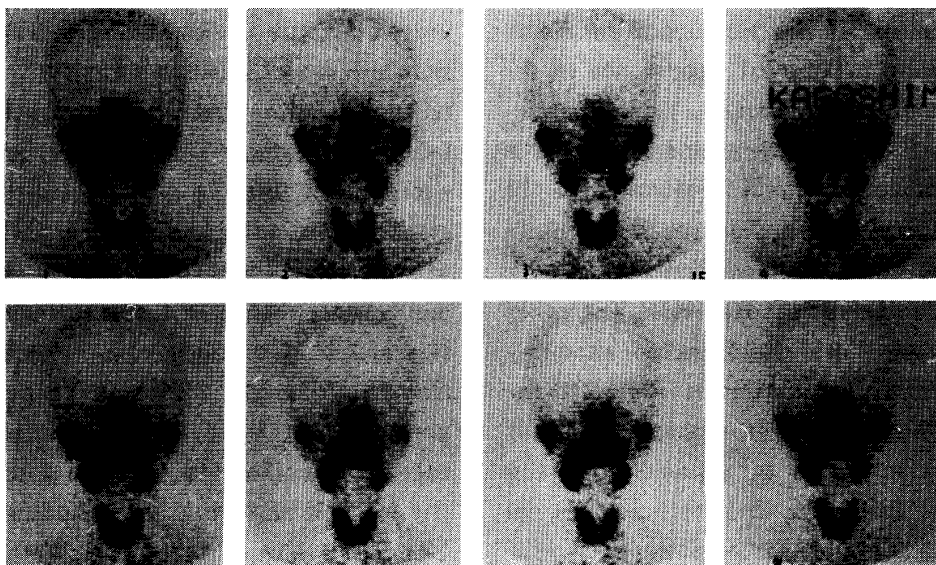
Sequential Sialoscintigraphy
